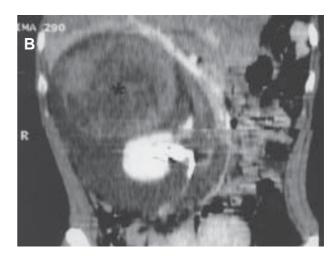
A) Computerized tomography (CT) of abdomen with contrast medium evidencing a voluminous retroperitoneal hematoma in the peri-renal area (\*). Cross section. B) Abdominal CT with contrast medium evidencing renal integrity and the presence of a voluminous hematoma in the peri-renal area, as well as the presence of a voluminous expansive lesion with cystic content in the region of the adrenal gland (\*). Frontal section
